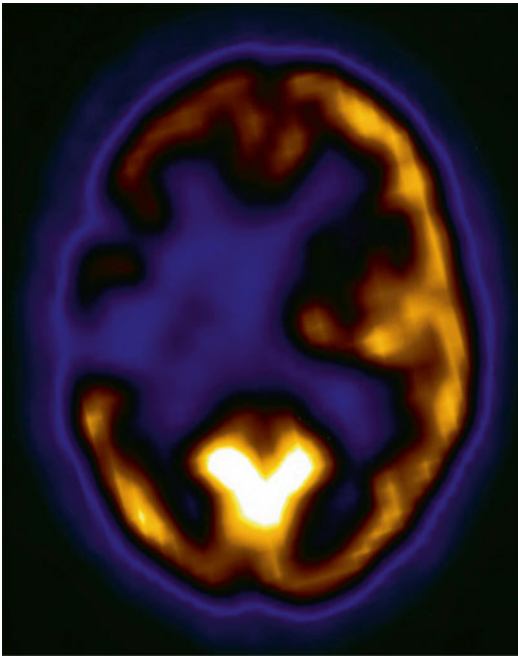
Metabolic imaging of FDG uptake using PET in a patient with an old distant right hemispheric stroke who made a remarkably good functional recovery without focal deficits on neurologic exam
